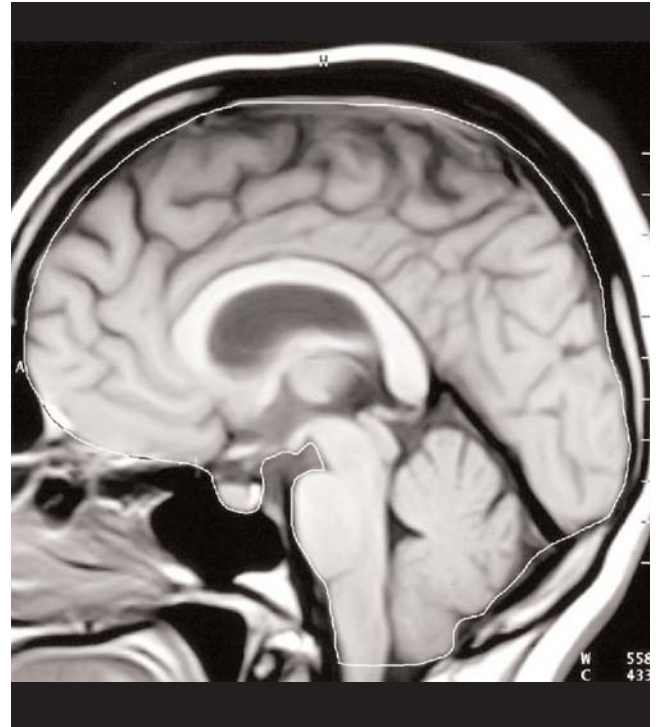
Intracranial measurement of mid-sagittal area of a subject. From "Morphometry of some elements of limbic system in normal population: a quantitative MRI study" by Yücel K, Hakyemez B, Parlak M, Oygucu IH. Neuroanatomy 2002;1:15–21.^[33] ©neuroanatomy.org. Reprinted with permission.
